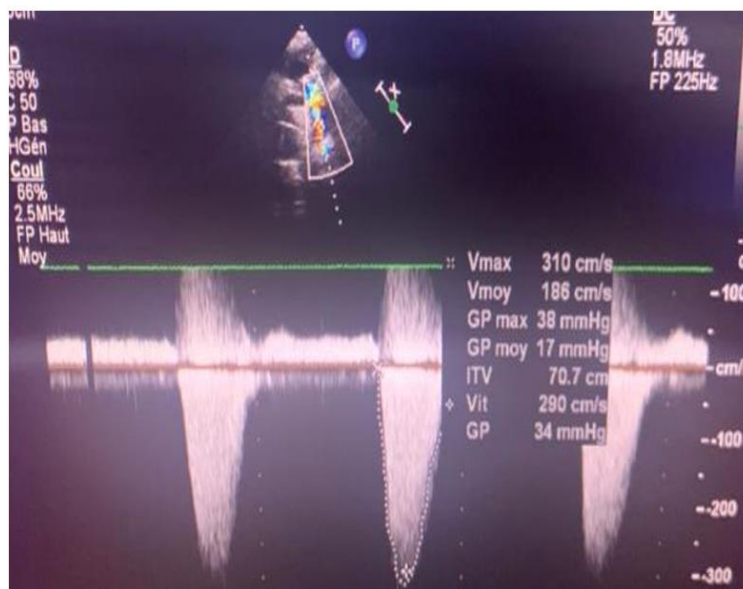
Cardiac ultrasound suprasternal section with continuous Doppler post stent: no diastolic extension.
